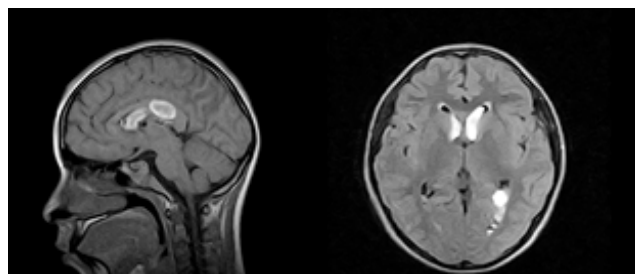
Brain MRI - FLAIR. A. Sagittal view and B. Axial view, showing hyperintensity corresponding to hemorrhage with lateral ventricular and temporal horn disruption.
